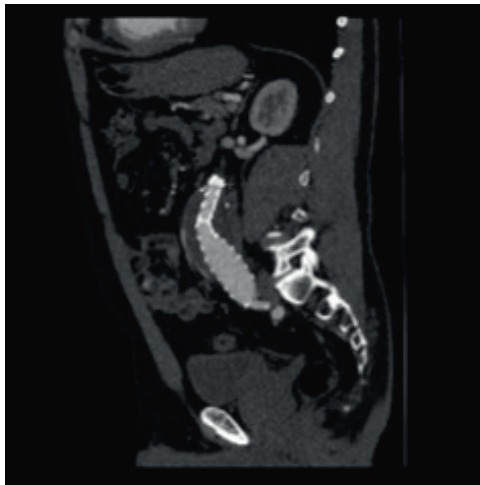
Postoperative computed tomography scan showing a stent graft in the correct position.
